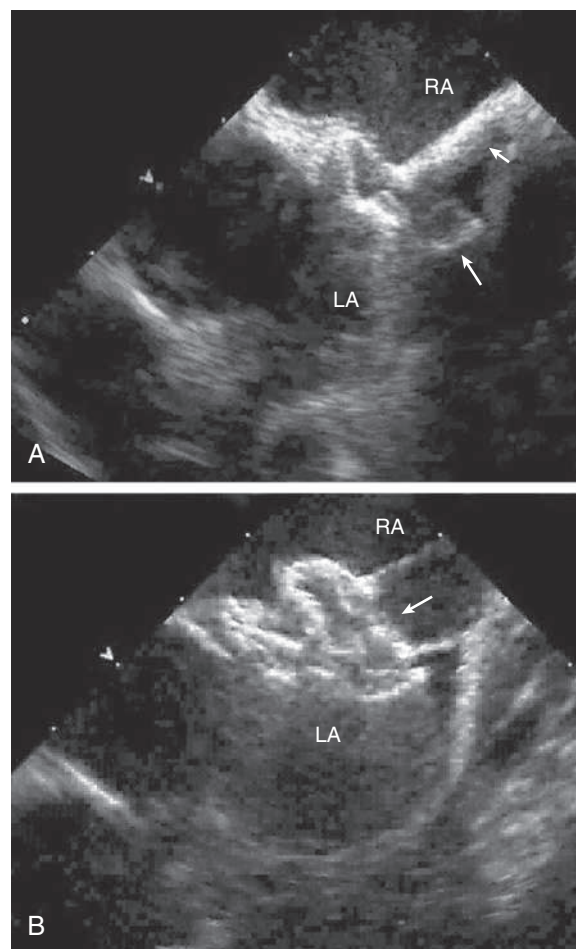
Intravascular ultrasound imaging of transcatheter occlusion of an atrial septal defect (ASD). A, Catheter (small arrow) has been advanced across the ASD, and the left-sided disk of the device (large arrow) has been extruded from the sheath into the left atrium (LA). B, The right atrial disk (arrow) has now been extruded into the right atrium (RA). The two halves of the device are then locked together and the catheter detached from the occluder device and removed.
